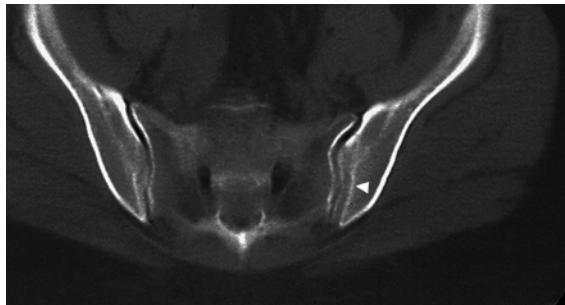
36-year-old woman with a bipartite iliac bony plate (arrowhead) unilaterally on the CT section.
